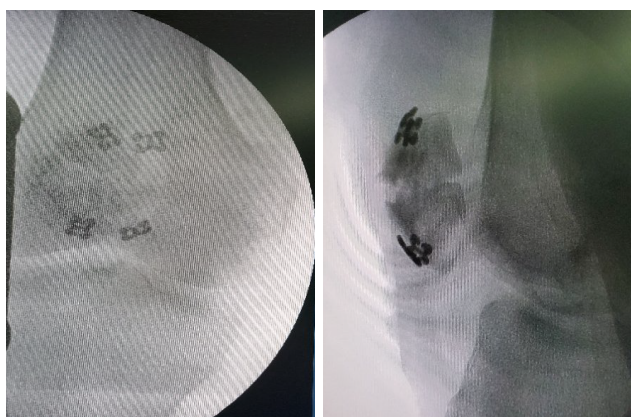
Intraoperative radiograph of double button plate fixation.
